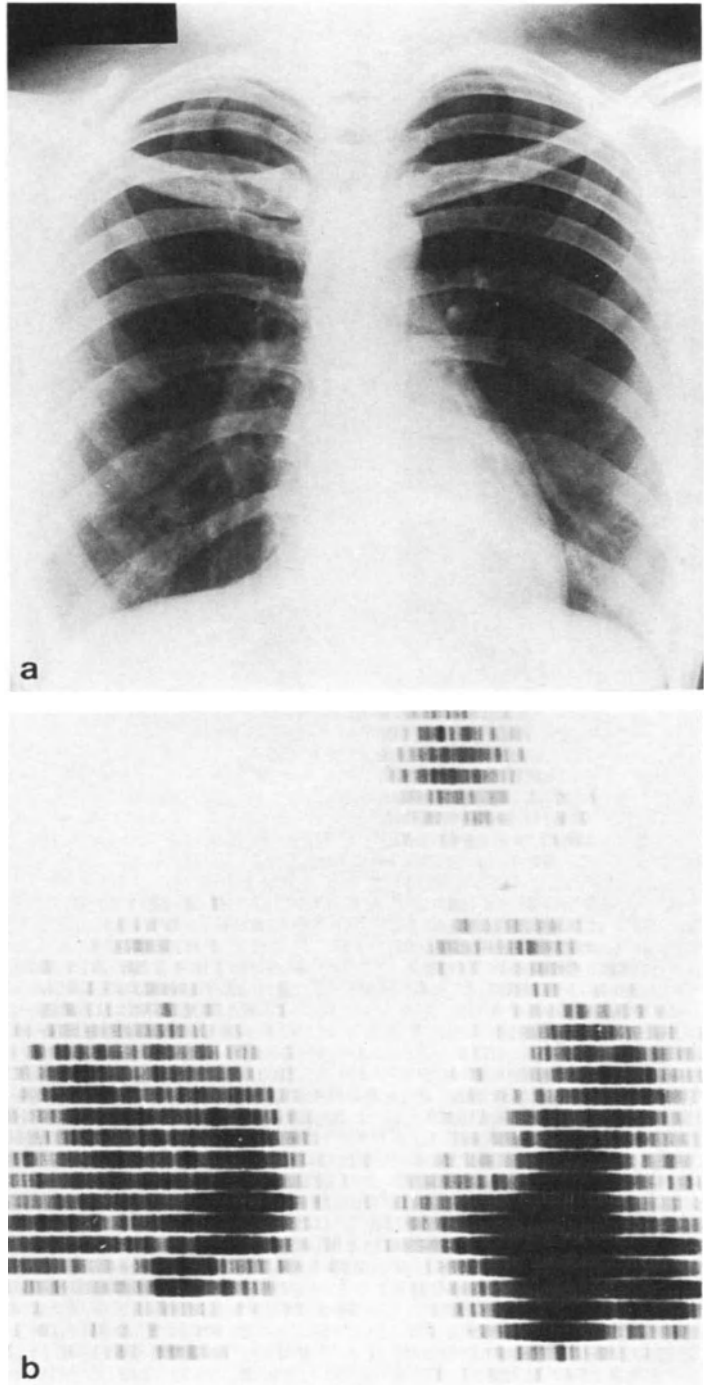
Functioning thyroid metastases in the lungs after total thyroidectomy. a Chest X-ray; b ¹³¹I scan
